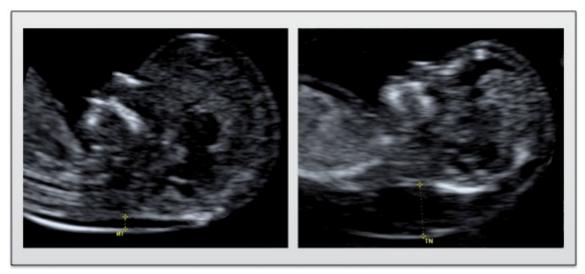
Ultrasound picture of 12-weeks euploid fetus with normal NT thickness (left) and trisomy 21 fetus (right) demonstrating increased subcutaneous accumulation of fluid behind the neck.
